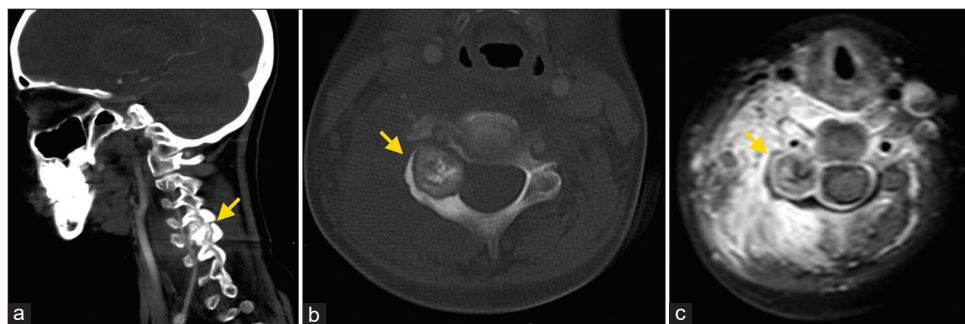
(a) Sagittal CT scan indicates the presence of a tumor (arrow) at the level of the C4–5 right pedicle and articular facet. (b) The inhomogeneous matrix ossification is presented in the tumor (arrow). (c) Gadolinium-enhanced axial MRI depicted a well-demarcated tumor (arrow) and edema of the paravertebral soft tissue.
